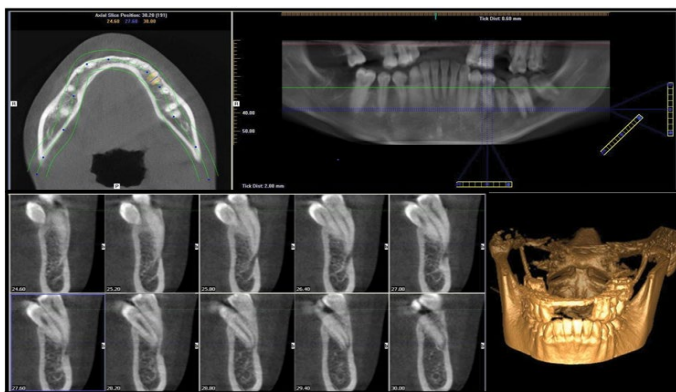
CBCT of first parapremolar.
